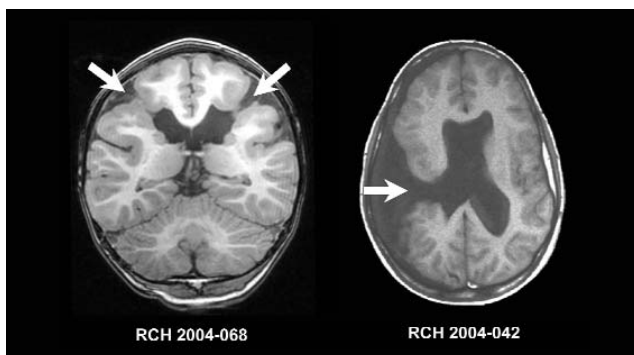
Imaging features of schizencephaly. Coronal T1- (left) and axial T1 (right)-weighted MRI scans. Both images show full-thickness clefts lined by irregular gray matter (arrows). The image on the left shows bilateral closed-lip schizencephaly (SCZ) and the image on the right shows right open-lipped SCZ and agenesis of the septum pellucidum. MRI, magnetic resonance imaging
